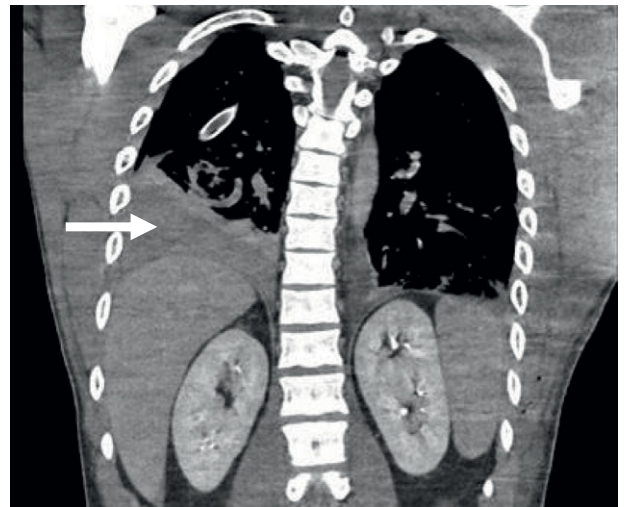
(a, b) CT images of right retained hemothorax (white arrows).
